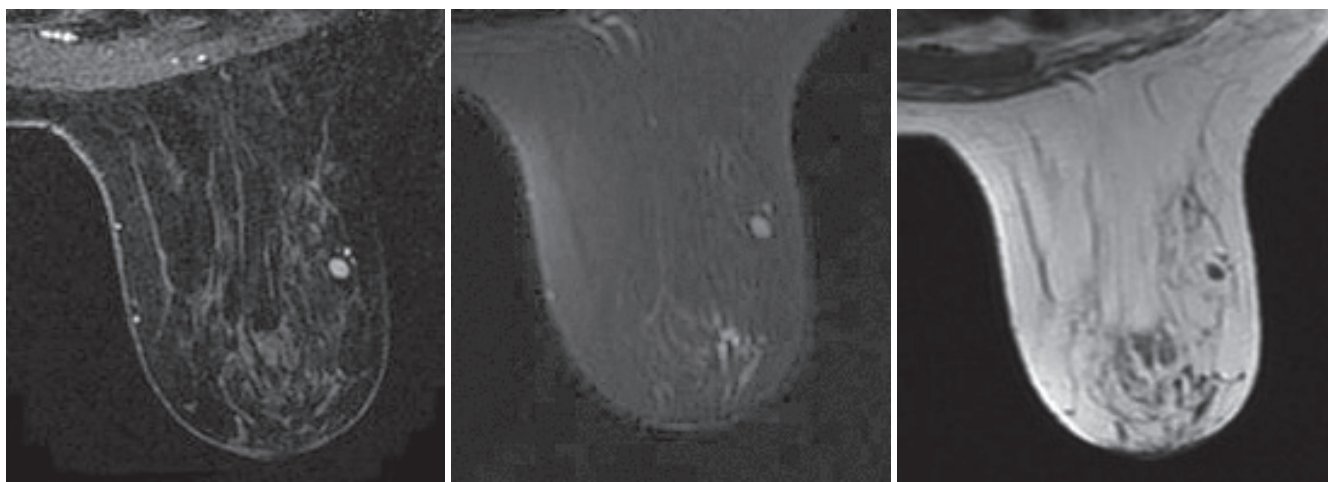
Stippled enhancement. Stippled enhancement during the arterial phase, with a diameter less than 5 mm. It can be identified as oval-shaped, with smooth margin and rim internal enhancement. Intramammary lymph nodes. Under high-resolution MRI, enhancements (even though it is less than 5 mm in diameter) with identifiable shape, margin, and internal enhancement should be managed as masses.
